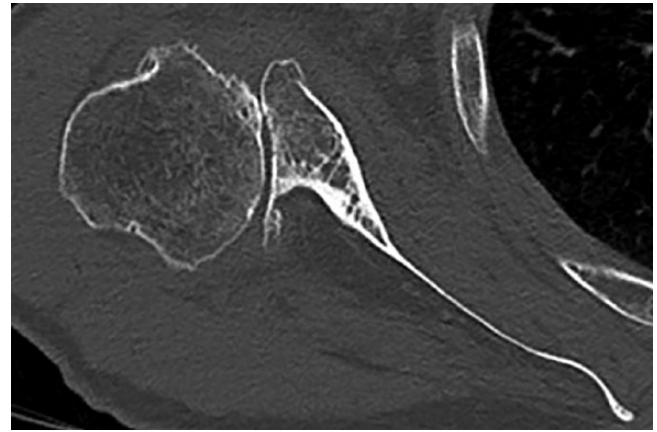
Osteoarthritis with posterior subluxation. Transverse CT image. The posterior subluxation of the humeral head is associated with substantial posterior erosion of the glenoid (type C in the Walch classification), making glenoid exposure through the deltopectoral approach difficult.
